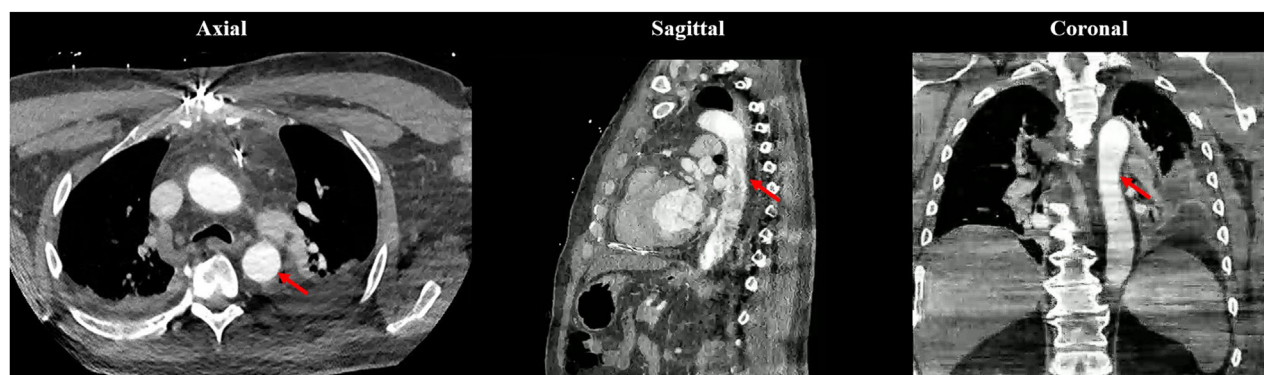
Contrast-enhanced thoracic computed tomographic angiogram, axial, sagittal, and coronal maximal intensity displays of the DTA (red arrows) obtained on postoperative day 1 confirm no evidence of an IAD.
